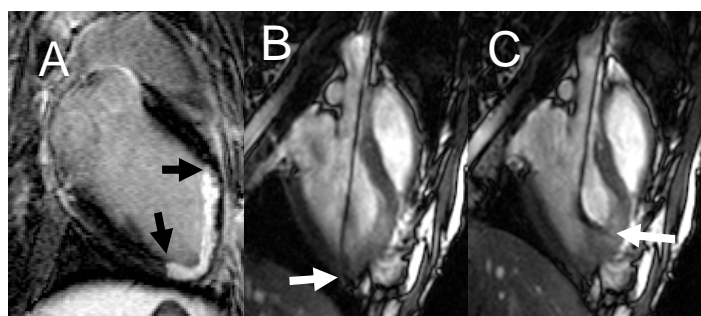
CE-MR image (A) shows hyperenhanced infarcted myocardium as a target for delivering therapy (arrows). Real time images (B, C) show the endovascular catheter in LV (arrows).
